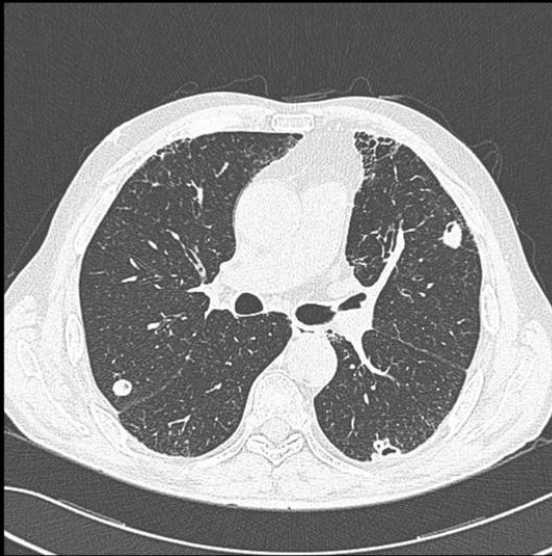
Axial CT shows peripheral well-defined nodules with areas of cavitation. There are findings of concomitant fibrosis in anterior subpleural location in the upper lobes.
